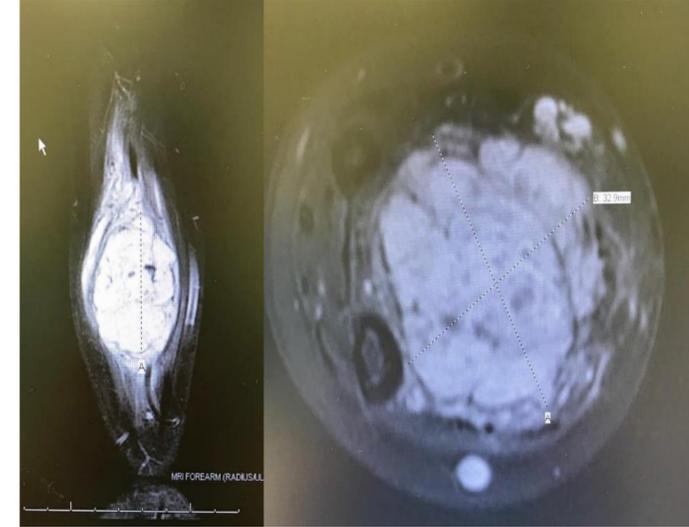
A-B. Magnetic Resonance Imaging demonstrating an intramuscular hemangioma encompassing the entire volar forearm compartment.
